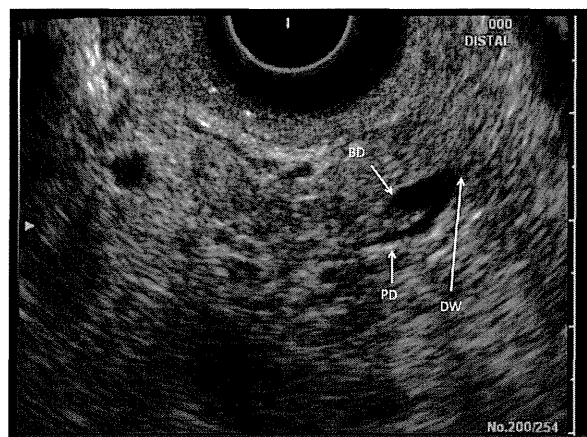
Endoscopic ultrasonography findings of pancreaticobiliary maljunction. The pancreatic duct (PD) and bile duct (BD) join anatomically outside the duodenal wall (DW).
